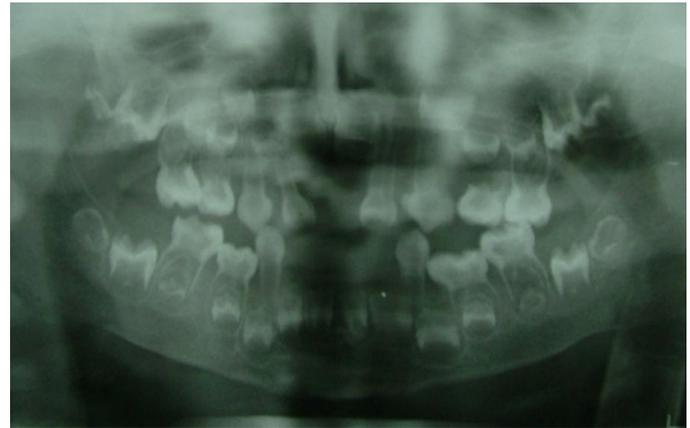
Initially panoramic radiography showing primary mandibular right second molar's caries and periapical radiolucency on the mandibular primary left second molars. Also, having similar to the taurodontic aspects in all primary first and second molars.
